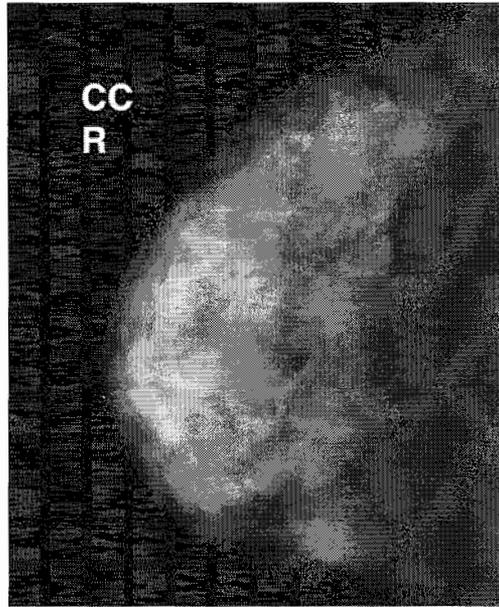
Dense fibrocystic changes as seen in X-ray mammogram (courtesy of Ville Marie Breast Center).
